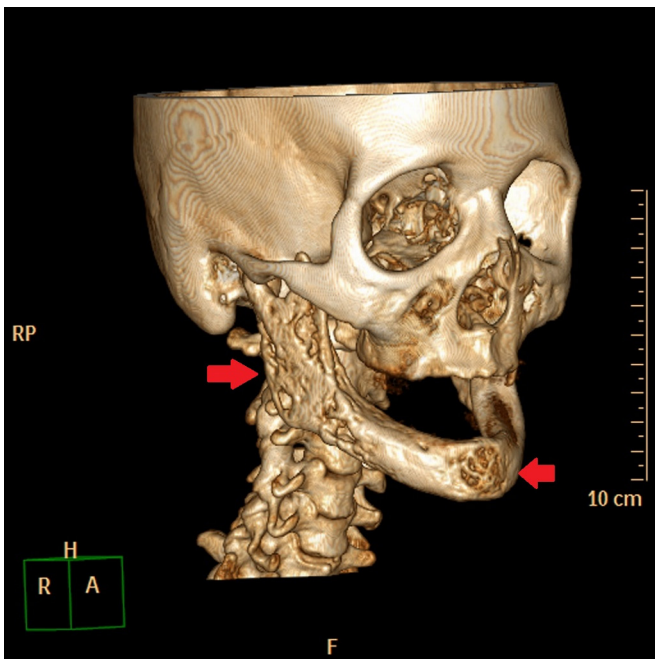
CT imaging with 3D reconstruction: osteolytic lesions in the mental region and in the right posterior mandibular region (red arrows show areas of structural loss of the cortical bone).
